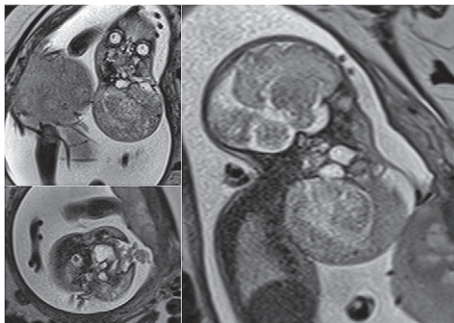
Magnetic resonance imaging T2-weighted sequence (coronal, axial and sagittal) shows a heterogeneous cervical mass extending from the oral cavity to the cervical region.
